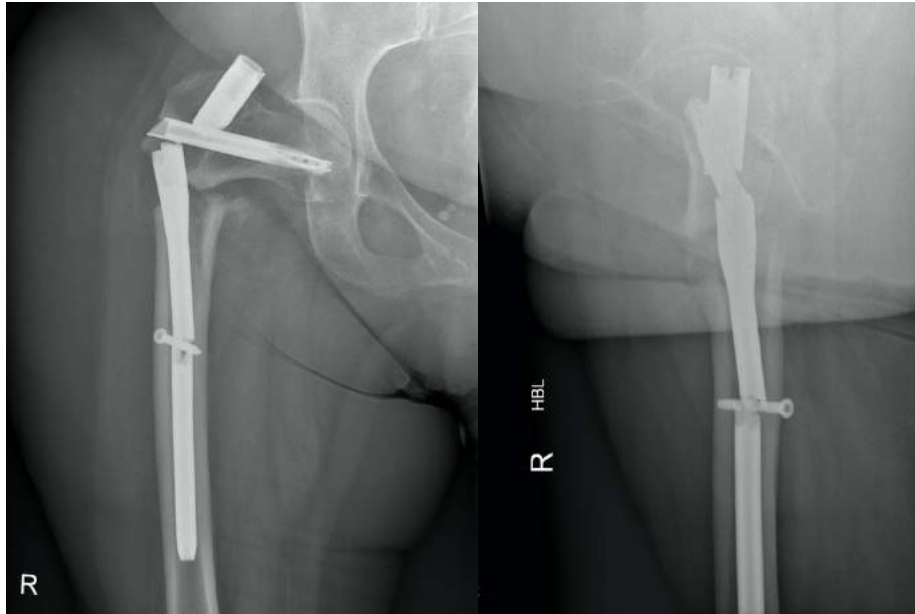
Post Breakage X-rays of Case 5
